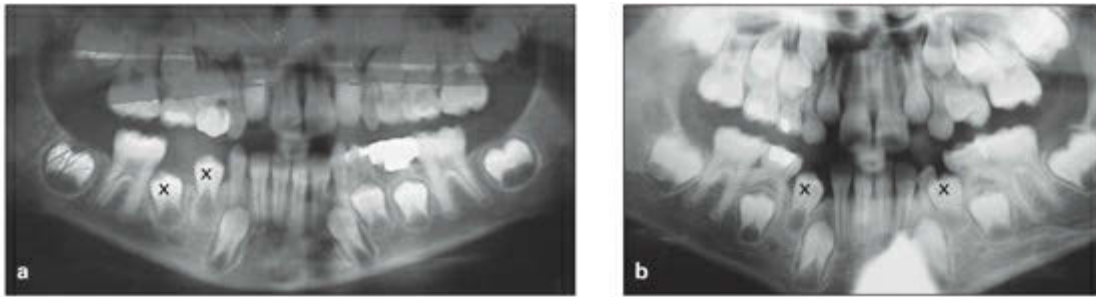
(a) Panoramic radiograph of a 7-year-old child whose primary right molars have been lost due to long abscess. (b) Loss of the molars caused early eruption of the premolars, which have short roots, are mobile, and require maintenance, such as a lower holding arch, splinting, or bonding.
